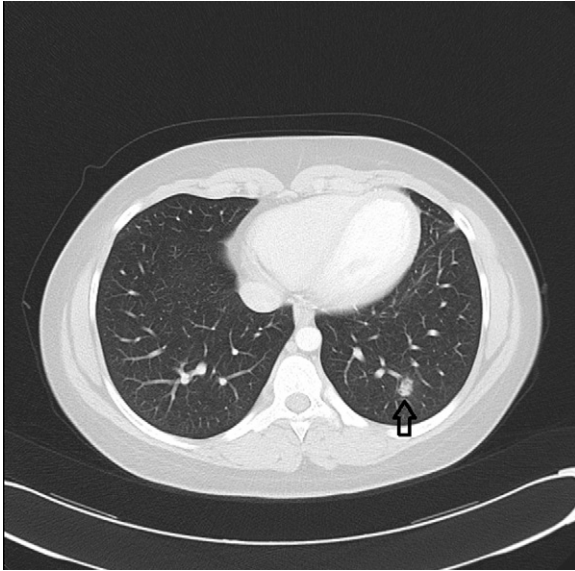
Computed tomography scan showing nodular opacity in the left lung.
